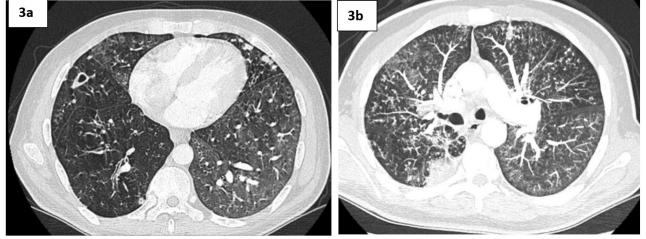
Chest CT scan in axial section, lung window showing a nodular infiltrate, some of which are excavated in the middle lobar and lingular regions (3a) and micronodular with centrilobular distribution (3b)
